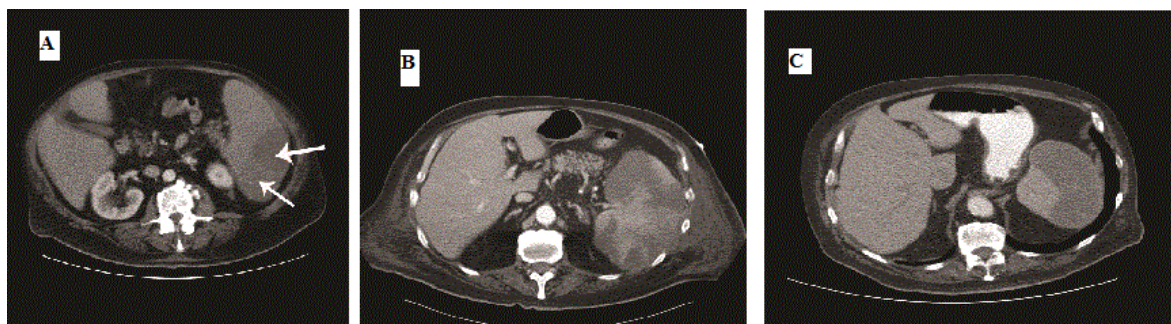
1(A): Initial CT scan at presentation with splenomegaly (17 cm × 11 cm × 17 cm) and two hypo-echoic nodules in the spleen suggestive of infarct versus tumor lesions.(B) Interval 2 weeks CT scan (prior to chemotherapy initiation) demonstrating an increase in number of the splenic lesions without an increase in spleen size.(C) CT scan on completion of chemotherapy with resolution of all splenic nodules but persistent defect consistent with splenic infarct.
